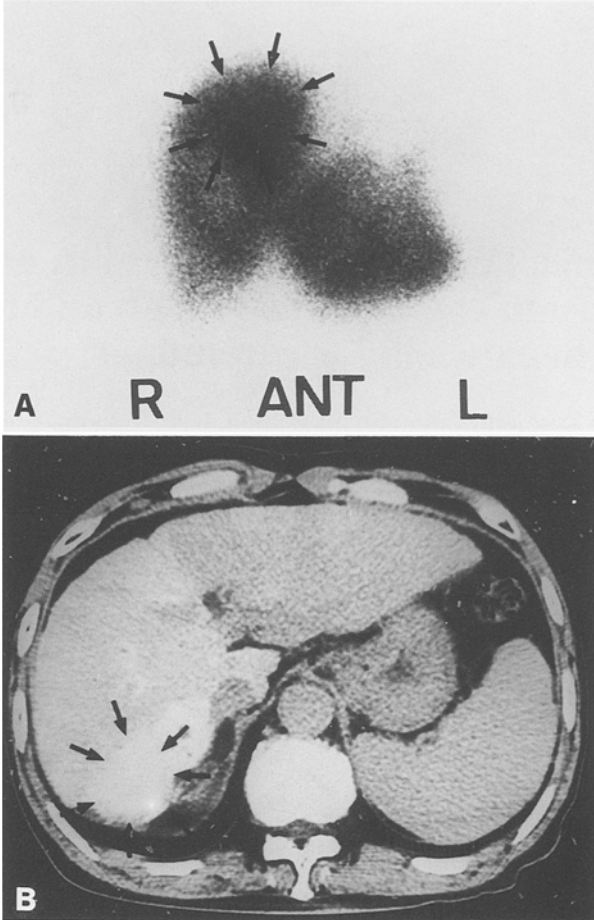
A A CT image of injected contrast medium from the reservoir shows a strongly enhanced tumor (*arrows*). B A scintigram obtained after the injection of 3 mCi ^{99m}Tc-MAA indicates that the radioisotope remains within the liver, accumulating strongly therein (*arrows*)
